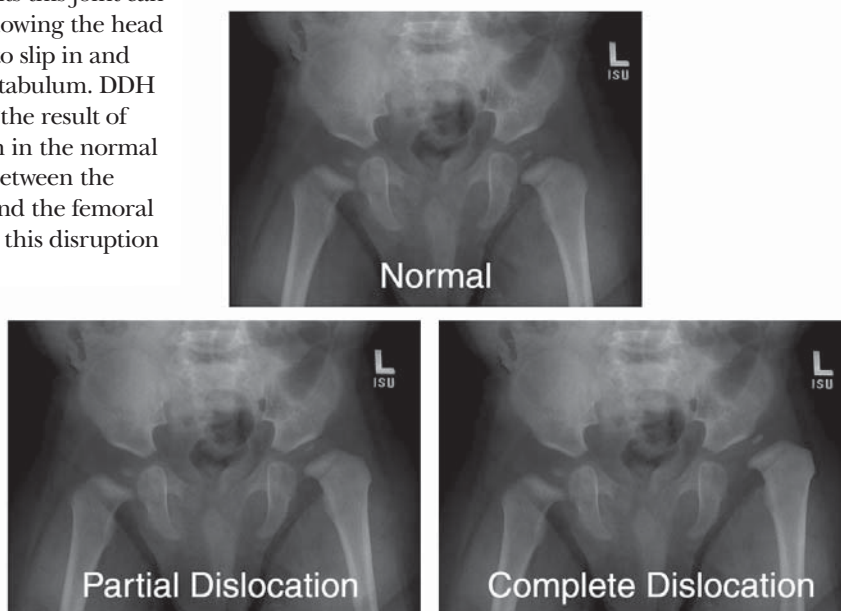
AP radiographs of the hip demonstrating a normal hip, partial dislocation and complete dislocation of the left hip.
